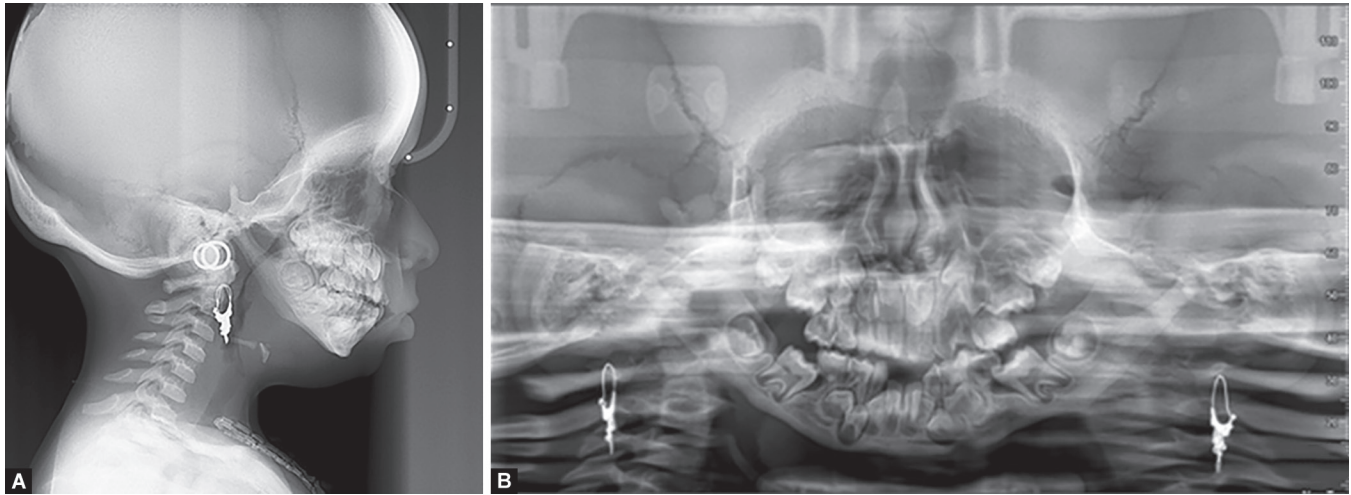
to G: Case 2, (A to E) Facial assessment; (F) Short stubby digits with dysmorphic nails; (G) Sandal foot deformityFigs 10A to C: Case 2, pretreatment radiographs (A) Lateral cephalogram; (B) Posteroanterior cephalogram; (C) Orthopantomogram
